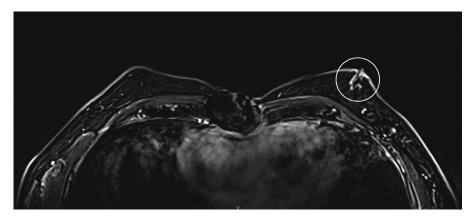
Male DCIS on MRI. Dynamic contrast-enhanced MRI first postcontrast subtraction image demonstrated left retroareolar breast linear non-mass enhancement in a segmental distribution extending to the left nipple, corresponding to the patient's reported bloody left nipple discharge. Subsequent surgical excision demonstrated DCIS.
